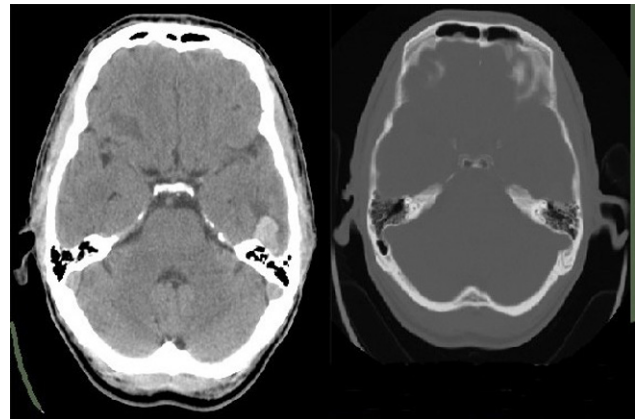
Initial CT of the patient revealed petrous fracture on the right temporal bone and left temporal parenchymal hemorrhage caused by contrecoup head injury.
